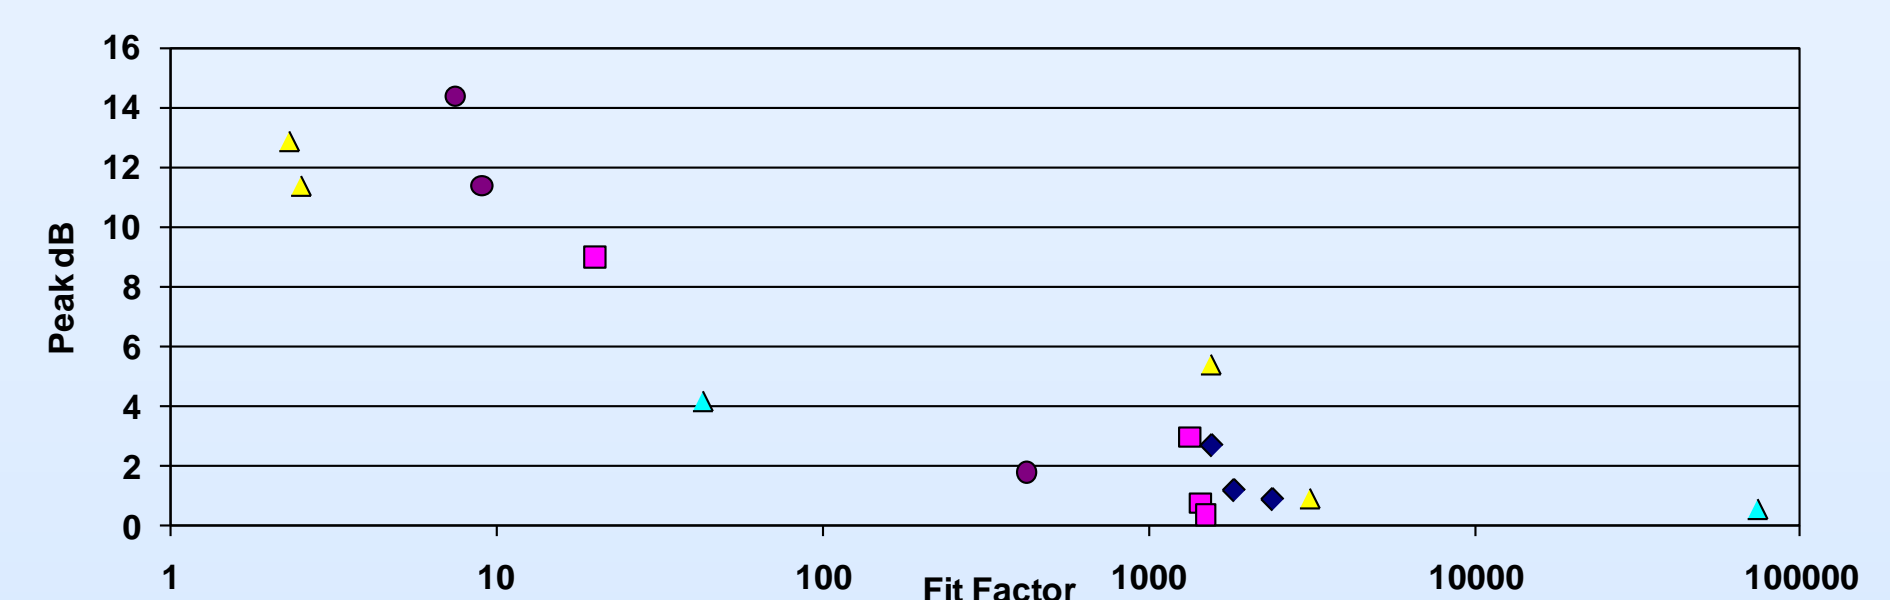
Ultrasound Leakage versus Protection Factor for Elastomeric Half-mask Respirators
